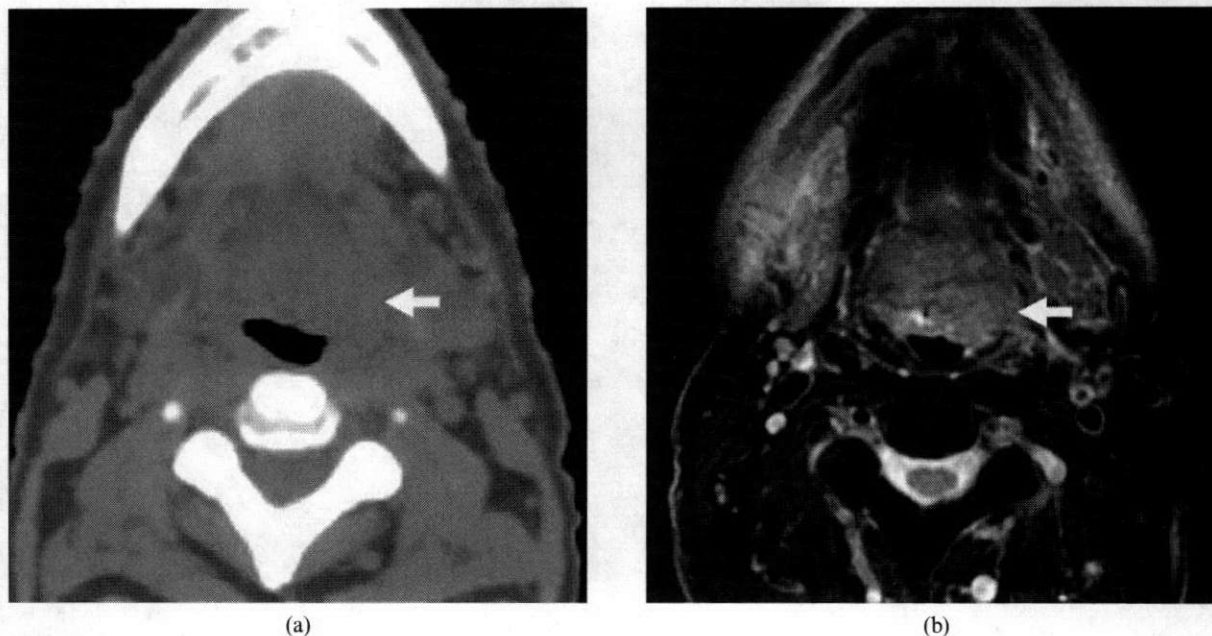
A case of a base of tongue cancer imaged with (a) CT and (b) MRI showing a large mass on the left side of the oropharynx involving the base of tongue and the left tonsillar fossa with invasion of the left parapharyngeal space. The base of tongue mass extends past the midline. These features are better visualized using MRI than CT.
